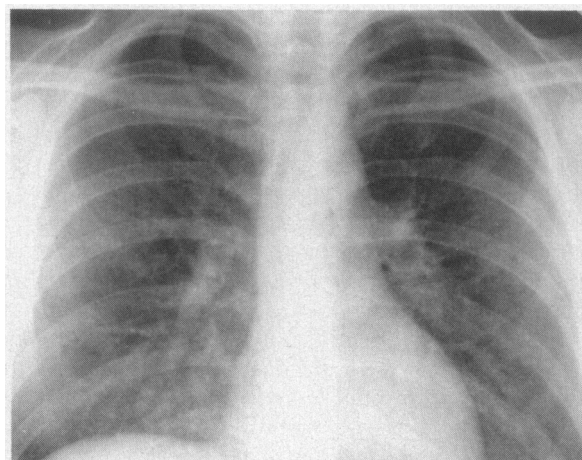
Radiograph of the Chest Obtained Four Months before Admission, Showing Mild Diffuse Linear and Ground-Glass Opacities in the Lungs.
